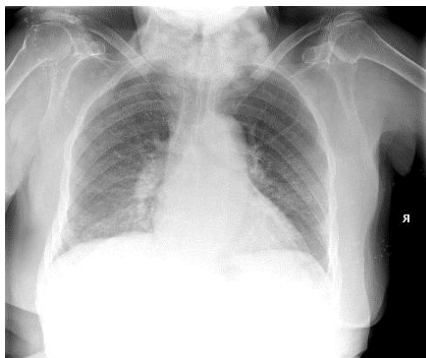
Chest X-ray three days after receiving antifungal
